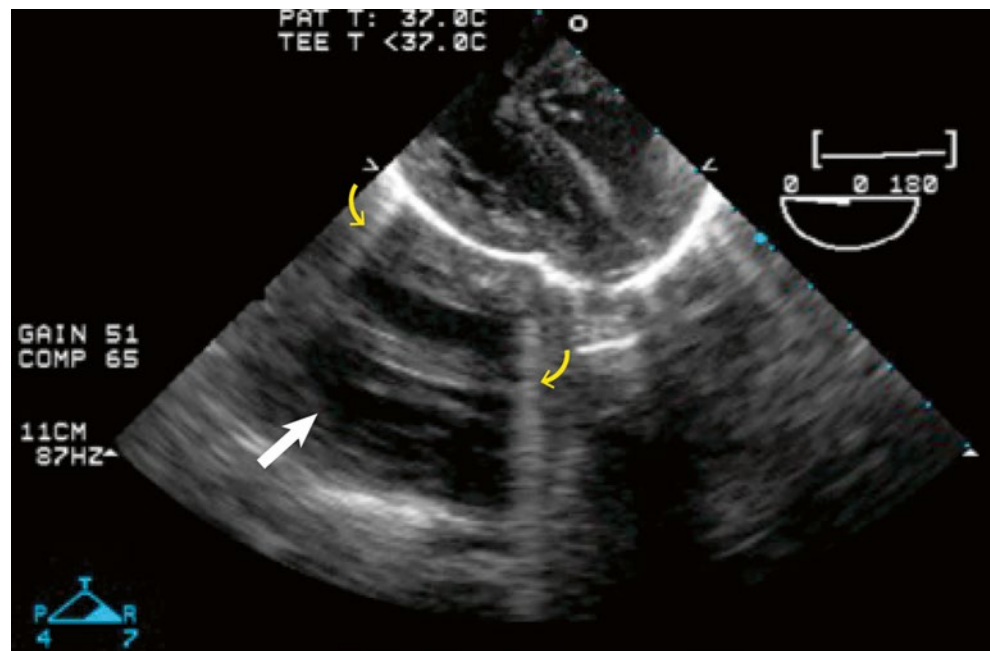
Example of a mirror image artifact (white arrow) from a transesophageal echocardiogram in a mid esophageal four chamber view. The mirror image is seen on the opposite side of a large specular reflector, in this case, pericardium. Comet tail artifacts (yellow arrows) are also seen
